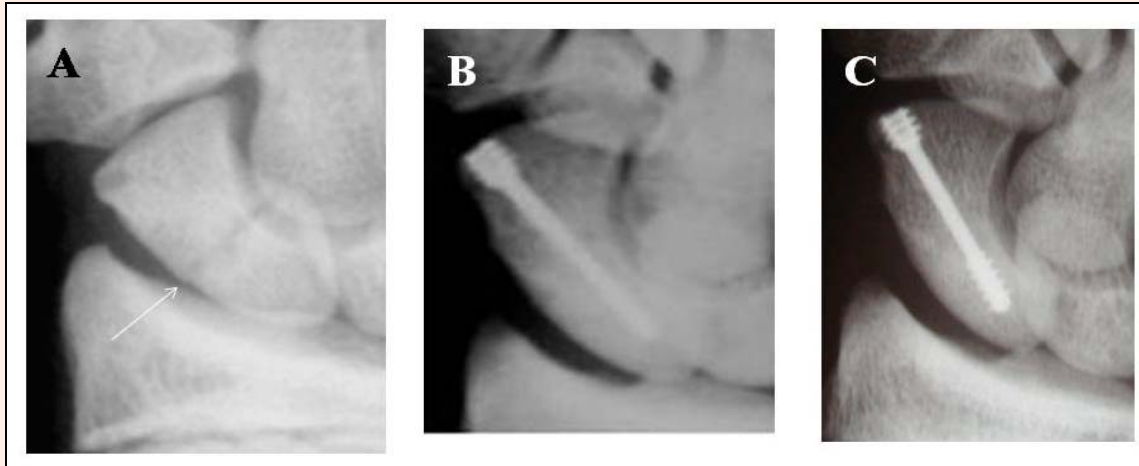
Radiographs before surgery (A), at postoperative two months (B), and at postoperative one year (C). A displaced fracture line (an arrow) was detected at the waist of the scaphoid (A). Union of the scaphoid was confirmed at postoperative 2 months and 1 year (B, C).
